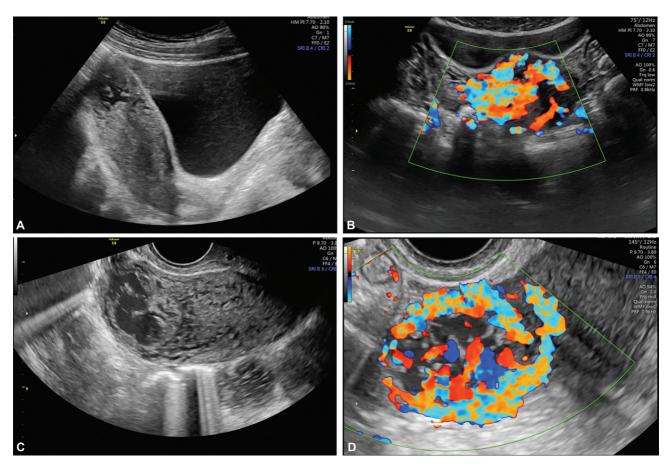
(A) Transabdominal ultrasound (right parasagittal view) reveals a round heterogeneous isoechoic lesion with a central anechoic sac in the fundus region near the right interstitial end. (B) Color Doppler revealed avid vascularity within the lesion. (C) Transvaginal sonography confirmed the predominant anechoic central areas within the lesion in the right interstitial end with (D) avid vascularity in most of the lesion and adjacent myometrium on Doppler mode.
